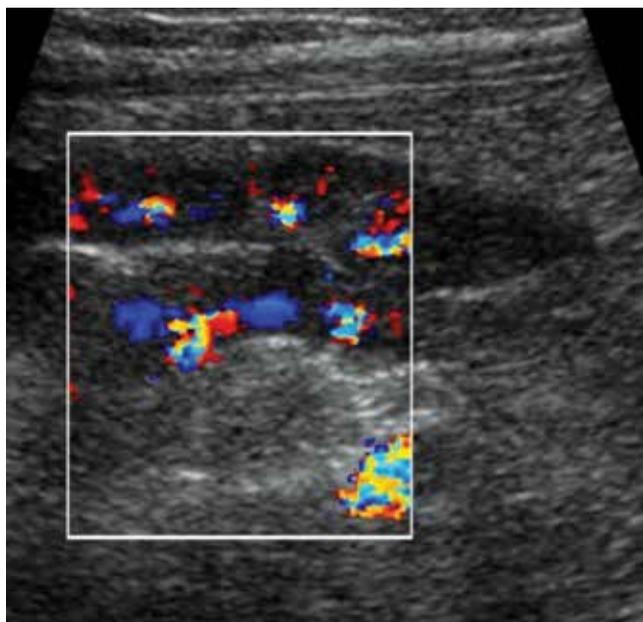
Doppler ultrasound image of the right iliac fossa showing a thickened loop of distal ileum, with intramural hypervascularity, consistent with active Crohn's disease.
